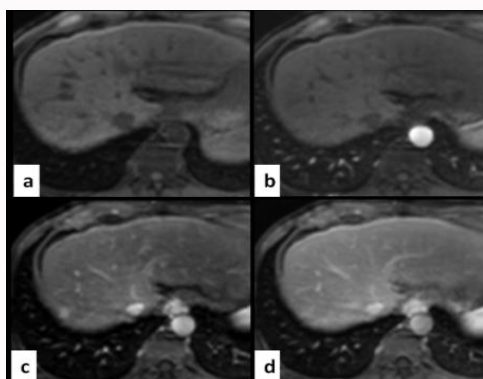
Dynamic MRI abdomen findings: Another well-defined lesion is seen in segment VII appearing iso-intense on pre-contrast T1 (a) and arterial phase (b). Homogenous enhancement is seen in portal venous phase (c) with no washout on delayed phase (d). Imaging findings are consistent with a dysplastic nodule.
